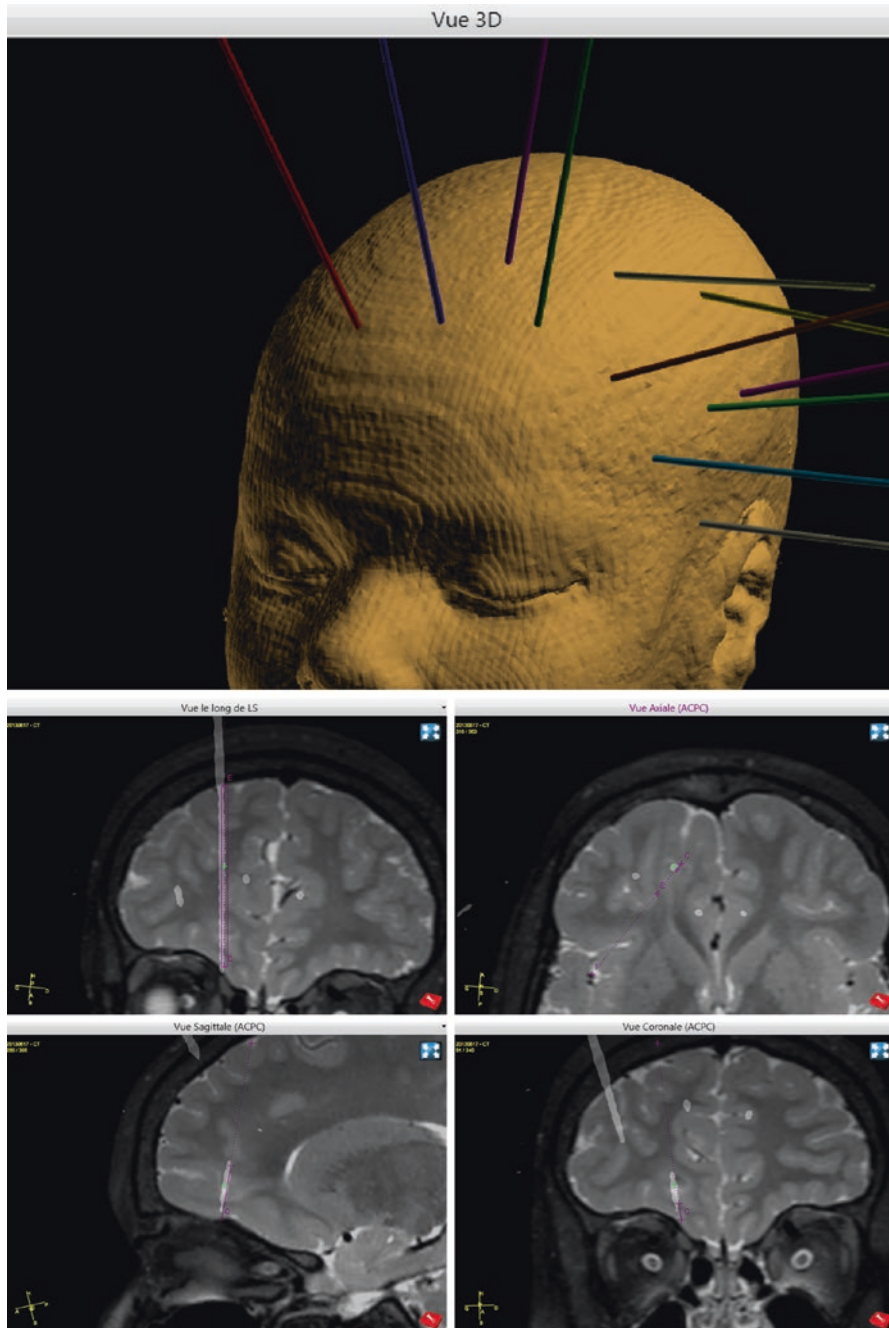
3D aspect of the orientation and skin entry point of all SEEG electrode trajectories. Below: Fusion of the MRI with a postoperative CT showing the implanted SEEG electrodes. The trajectory (purple line) of the electrode LS which traverses the lesion has a vertical orientation. Several smaller white spots correspond to contacts of nearby placed electrodes
